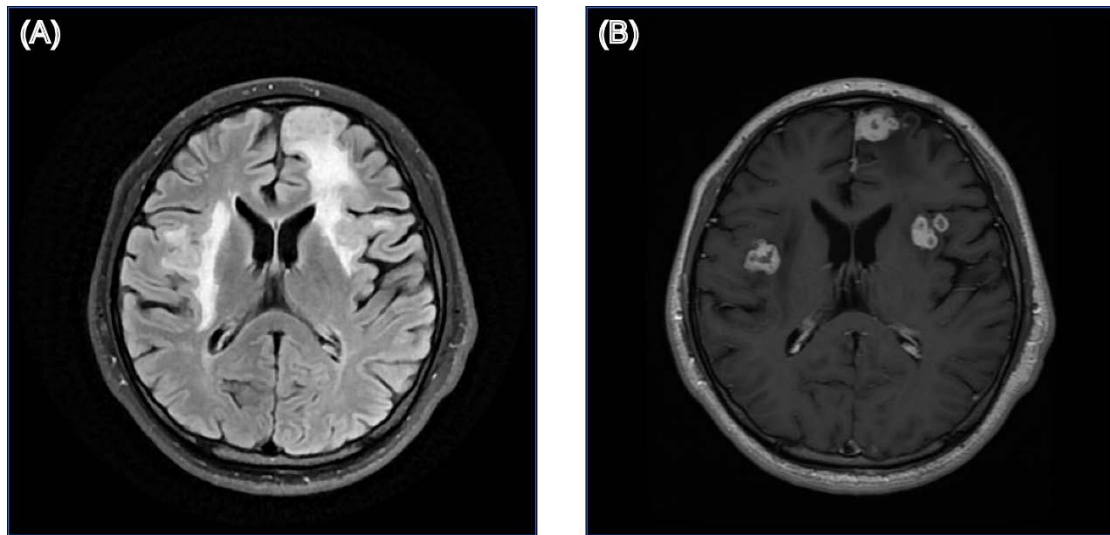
Structural brain MRI images of patient 08. (A) T2-weighted fluid-attenuated inversion recovery (T2-FLAIR) image; (B) Gadolinium-enhanced T1-weighted (Gd-T1w) image.
